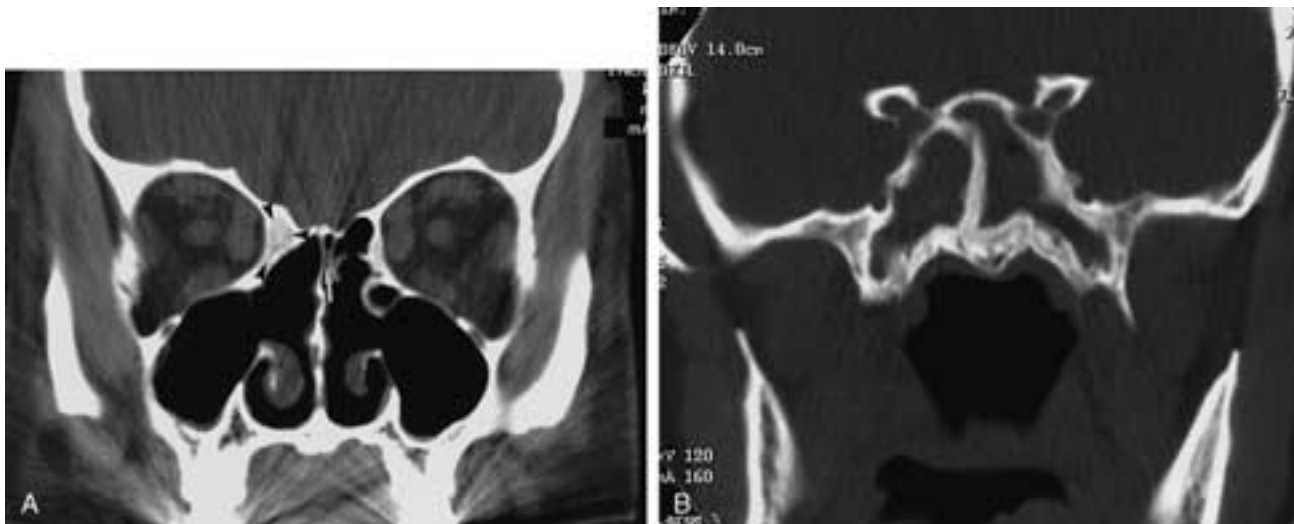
Failed FESS, two separate patients with osteitis. A, Coronal CT scan. At this level the maxillary ostia and infundibulum are widely patent, and the residual left middle turbinate is adherent to the nasal septum (*arrow*), a desired postoperative result, as the ethmoid infundibulum is patent. Note that at this level the entire right middle turbinate, even the vertical portion, has been resected. This observation should be reported in the dictation, as an important surgical landmark is gone. The dense sclerosis within the right ethmoid complex (*arrowheads*) is seen and represents a new finding. The significance of this physiologic bony change is not well understood, but it likely relates to chronic osteitis and inflammatory changes and is a common finding in patients with recurrent symptoms after FESS. B, Coronal CT scan. In this patient with recurrent sphenoid sinusitis after FESS, note the sclerosis of the sinus walls and the intersphenoidal septum.
